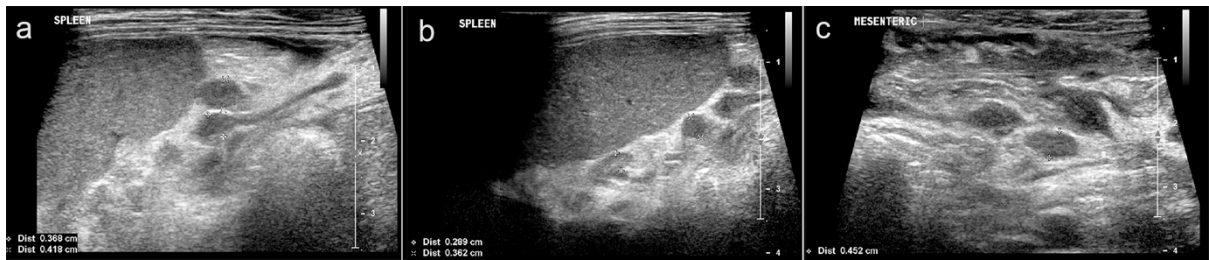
Sonographic images from an 8-year-old child in whom reviewers demonstrated discrepancy when reporting lymphadenopathy. (a-b) Perisplenic subcentimetre lymph nodes, some with a rounded morphology. c) Subcentimetre mesenteric lymph nodes with preserved morphology
